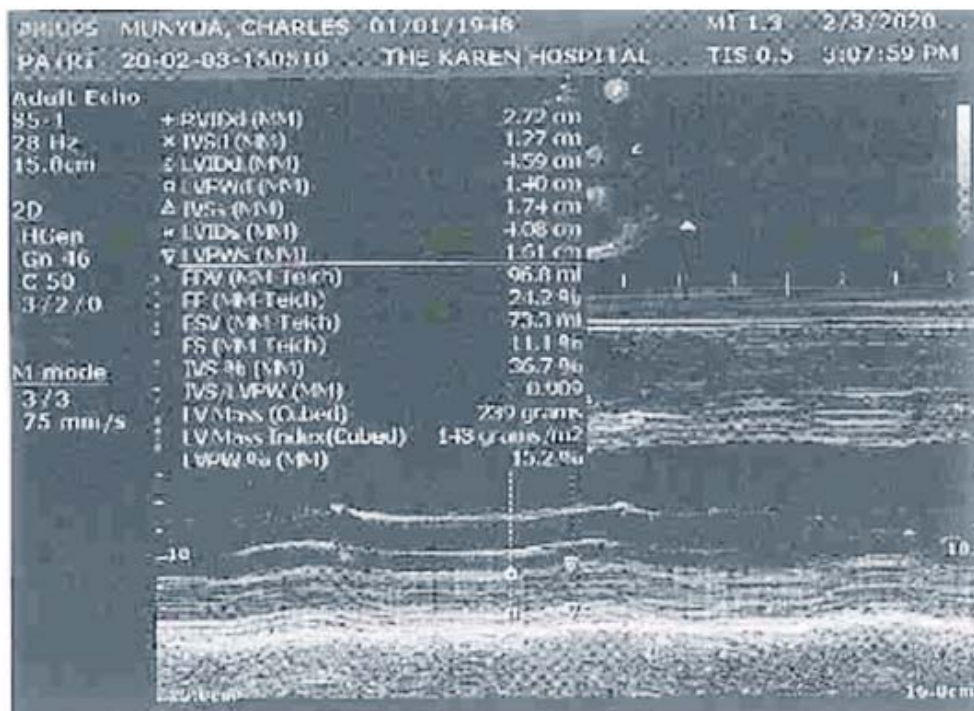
Echocardiogram depicting reduced ejection fraction
